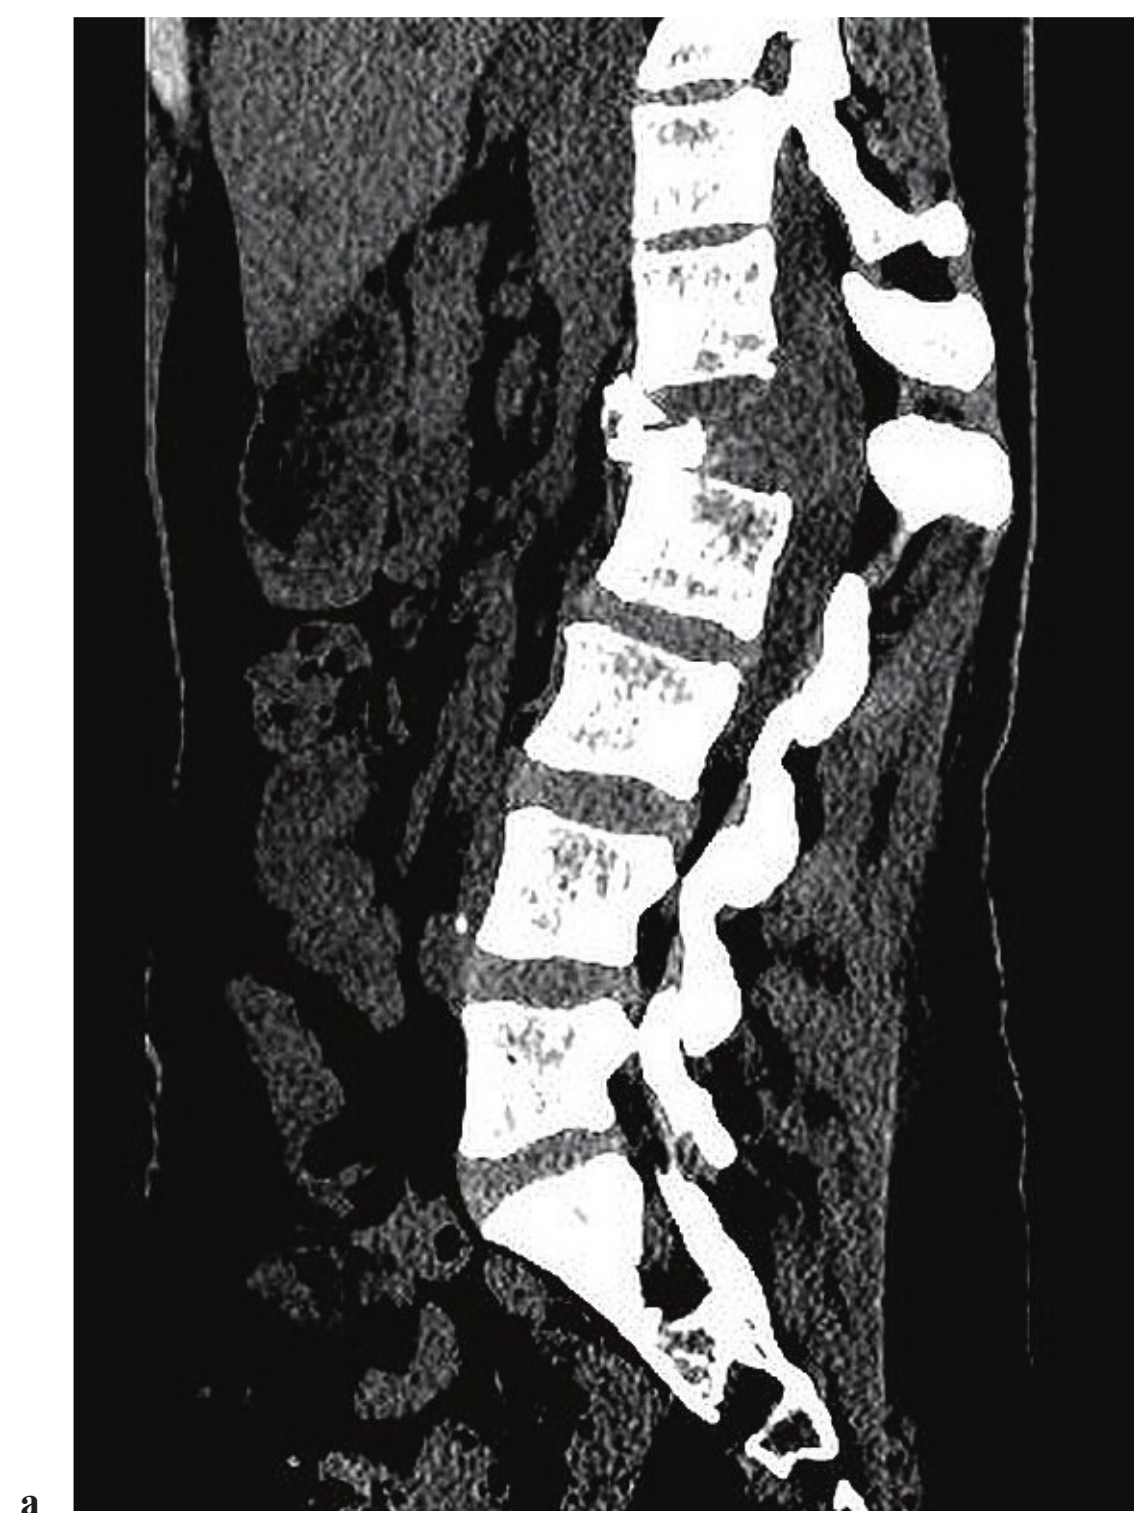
Metastatic epidural spinal cord compression. (a) Sagittal CT reconstruction and (b) axial CT image in a patient with known metastatic breast cancer with sudden paraplegia and incontinence after a fall. A large destructive L1 vertebral body lesion is also invading both pedicles, left more than right, with significant ventrolateral cord compression. There is a resultant kyphotic deformity at T12.
